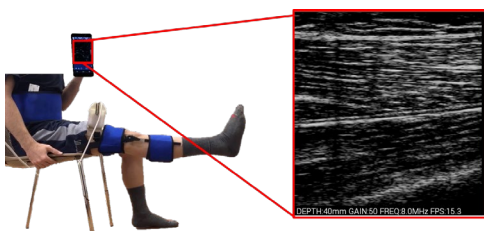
Experimental Setup. *Subject during experimental data collection with portable ultrasound device and goniometer in place (left). Representative ultrasound image of rectus femoris muscle (right).*
